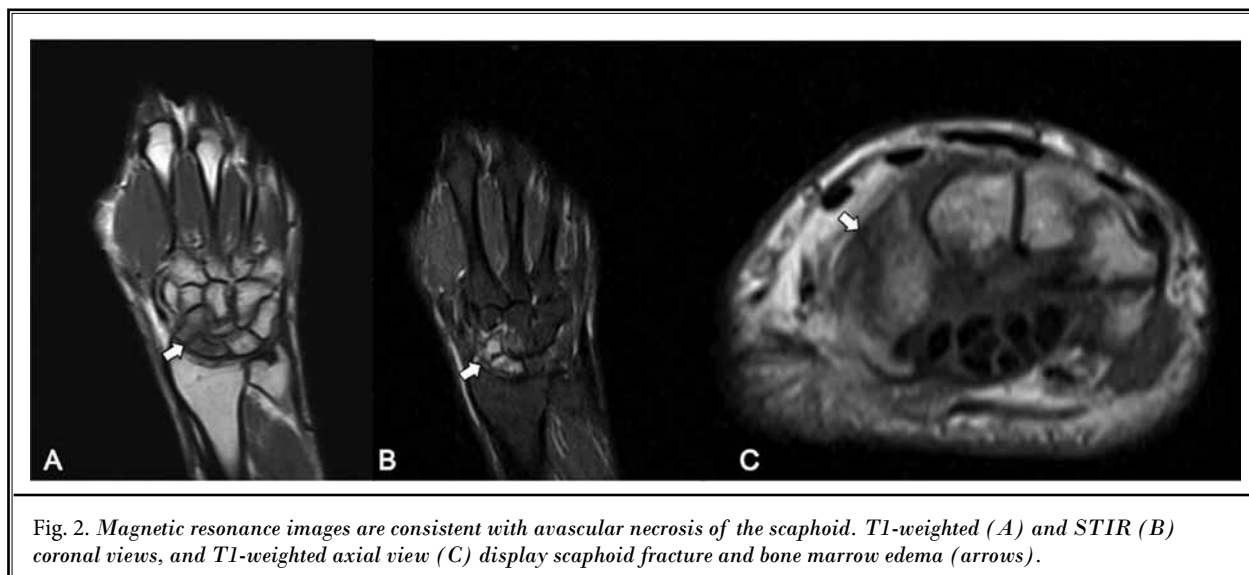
Magnetic resonance images are consistent with avascular necrosis of the scaphoid. T1-weighted (A) and STIR (B) coronal views, and T1-weighted axial view (C) display scaphoid fracture and bone marrow edema (arrows).
